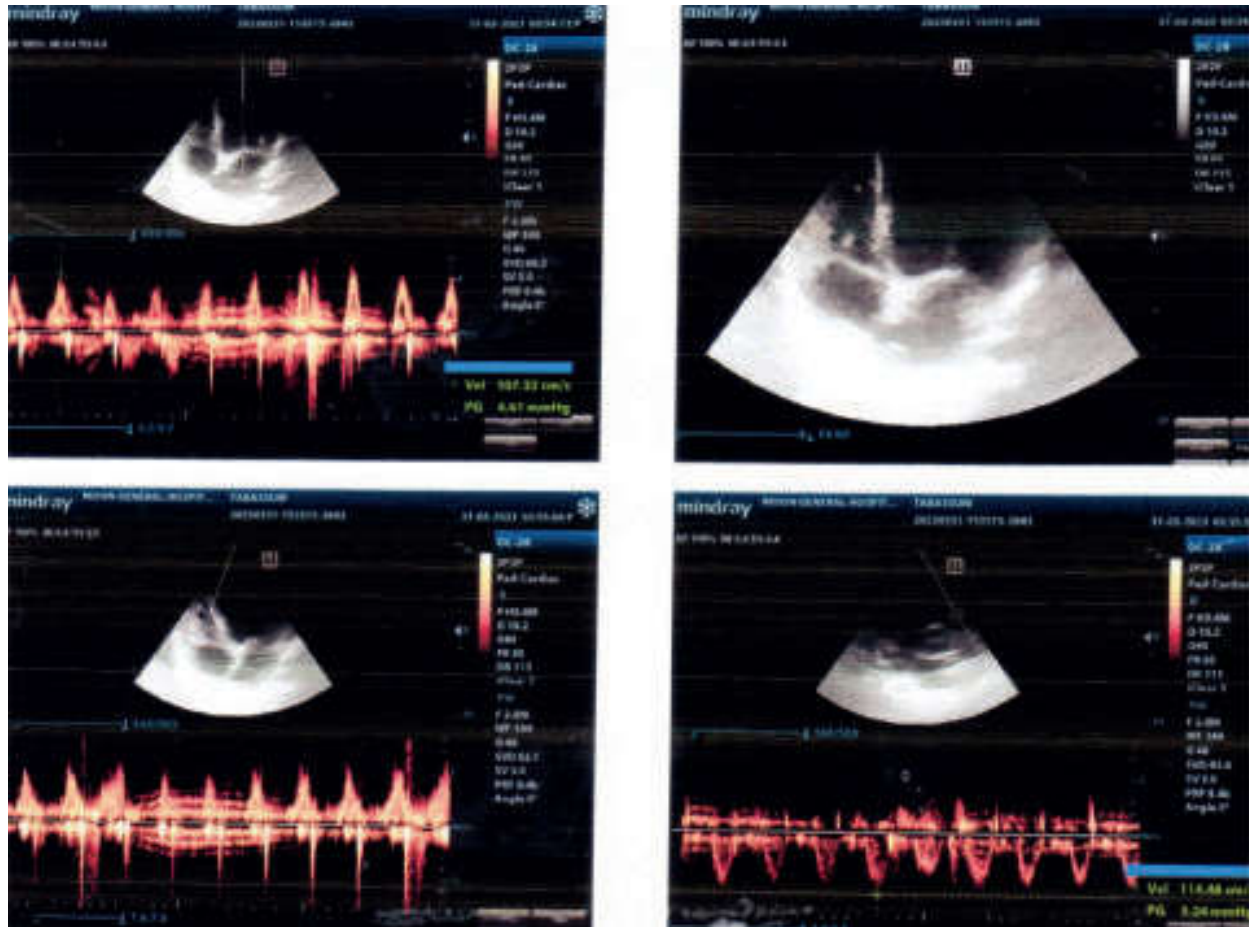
Echocardiography showed thickened mitral valve with calcification of anterior mitral leaflet & trivial tricuspid regurgitation. [Figure 5]
